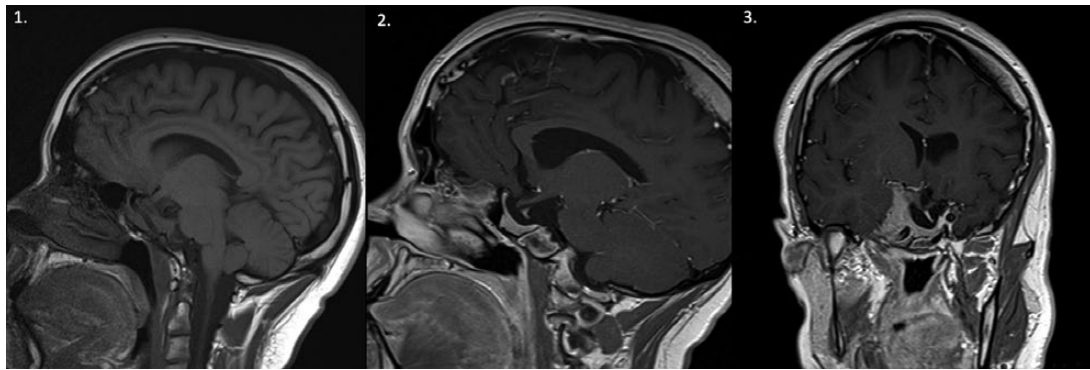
MRI of the brain at 15-month follow-up: sagittal T1 precontrast (1), sagittal T1 postcontrast (2), and coronal T1 postcontrast view (3) demonstrating significant reduction in the size of the tumor.
